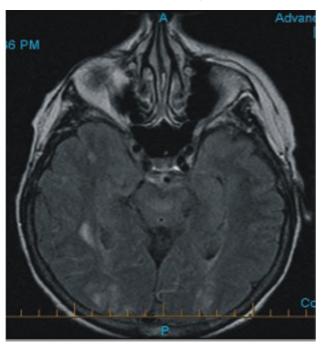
MRI Brain T2 image— shows hyperintense T2 signals in bilateral occipital and right parietal lobe regions .
